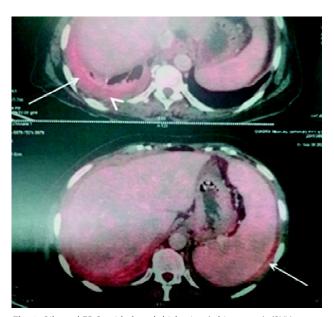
Bilateral FDG-avid pleural thickening (white arrow); (SUV max = 3, maximum pleural thickening 6.8 mm); right-sided pleural effusion also seen (white arrow head).
